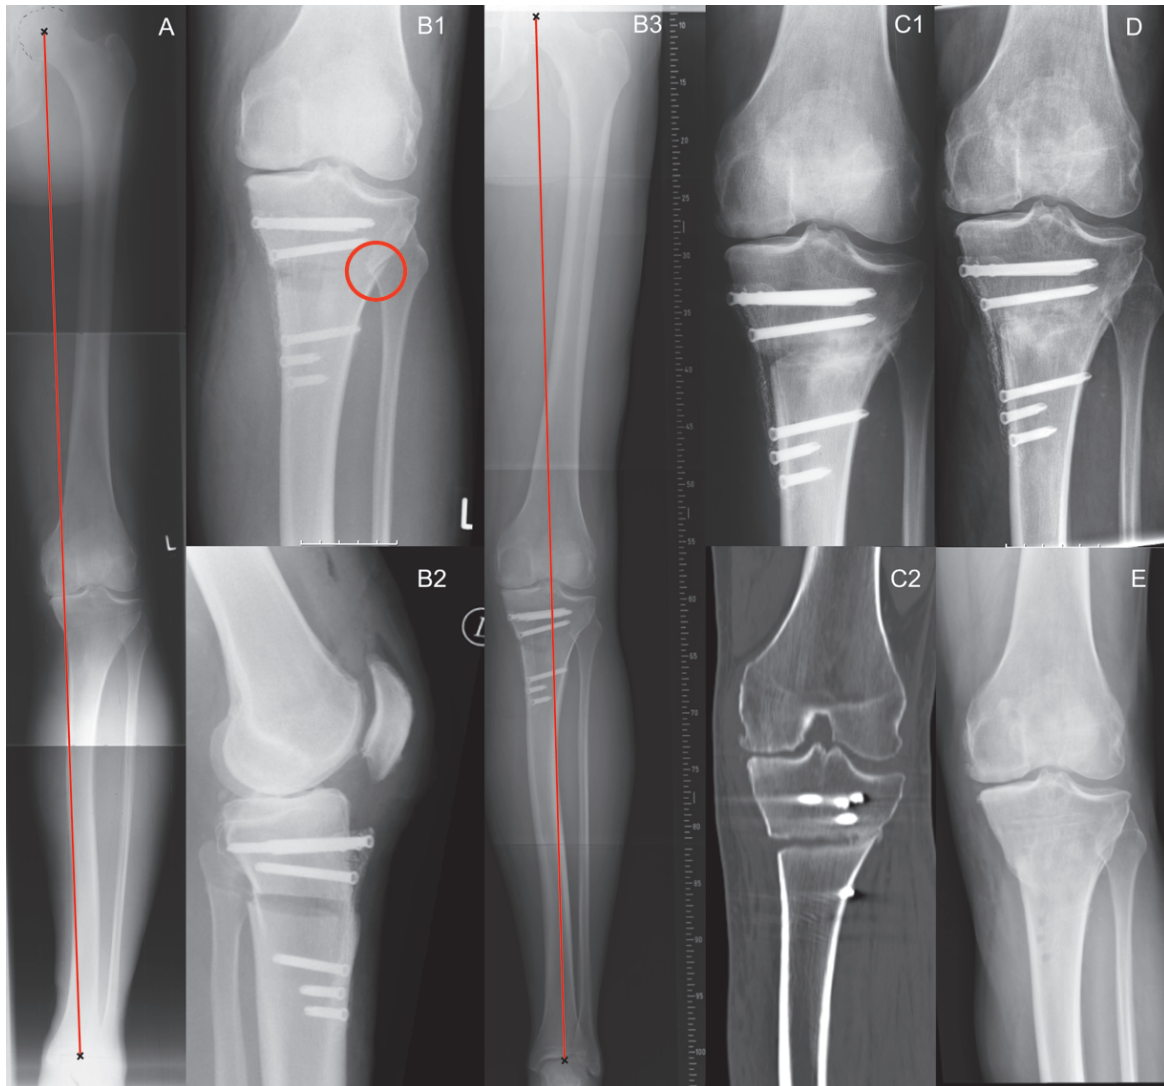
Although varus deformity (A, preoperative AP long-leg weight bearing radiograph) has been corrected sufficiently (B1 and B2, postoperative AP and lateral views; B3, postoperative AP long-leg weight bearing radiograph), the patient presented with persistent pain. Postoperatively, a fracture of the lateral cortex was observed (red circle, B1). 6 months after surgery a pseudarthrosis of the osteotomy gap was found on radiographs (C1, AP view; C2, computed tomography) and was treated with autogenous cancellous bone graft from the iliac crest. Five months after revision surgery, consolidation of the osteotomy gap was evident (D, AP view) and implant was removed 21 months after initial ow HTO. Complete consolidation (E, AP view).
